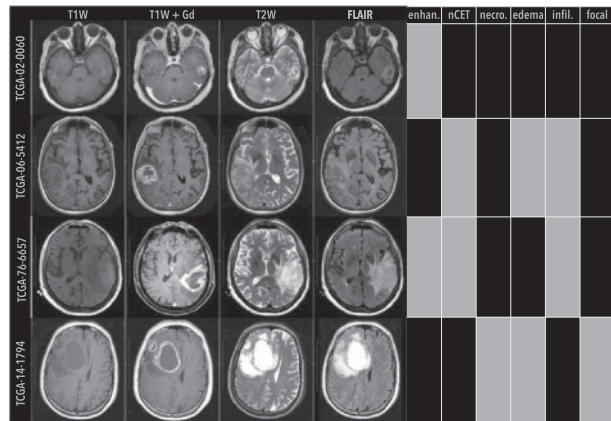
Examples of phenotypic differences observed in GBM patients. Shown are single, axial images of pre-op MRI scans from the TCGA–GBM cohort. Four MRI sequences were used to annotate tumor (white arrows) imaging traits: T1W, T1W+Gd and T2W and FLAIR images. MRI traits included enhancing (enhan.), nCET, necrosis (necro.), edema, infiltrative (infil.) and focal, where class labels were indicated by black (proportions < 1/3, expansive, or focal) or gray (proportions ≥ 1/3, infiltrative, or non-focal) blocks
